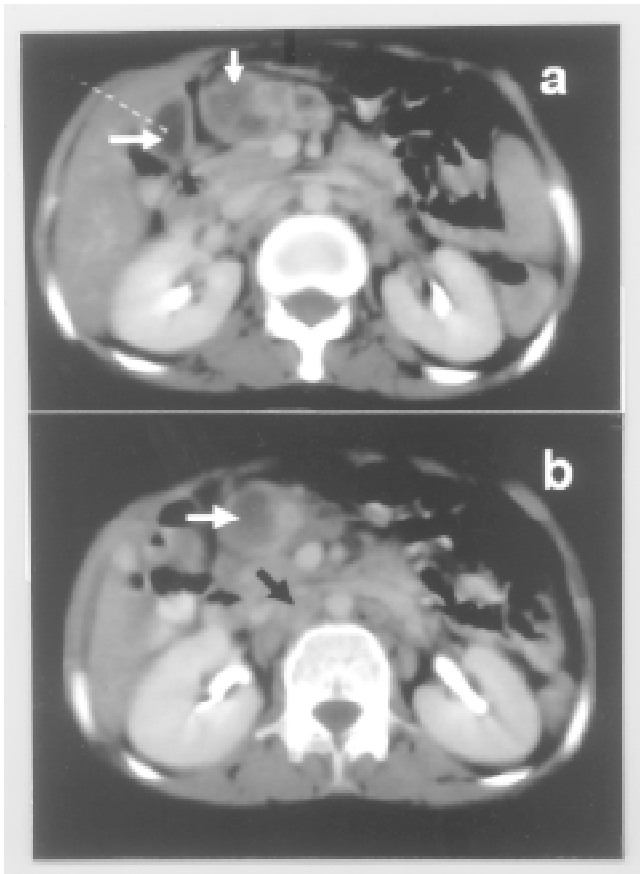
Contrast enhanced CT scan of the abdomen showing intraabdominal (a) and retroperitoneal (b) lymphadenopathy (arrows). Both the white and black arrows point to hypodensity which indicates necrosis in the lymph node. This central attenuation with peripheral rim enhancement is considered classical (though not pathogenomic) for tuberculosis.
